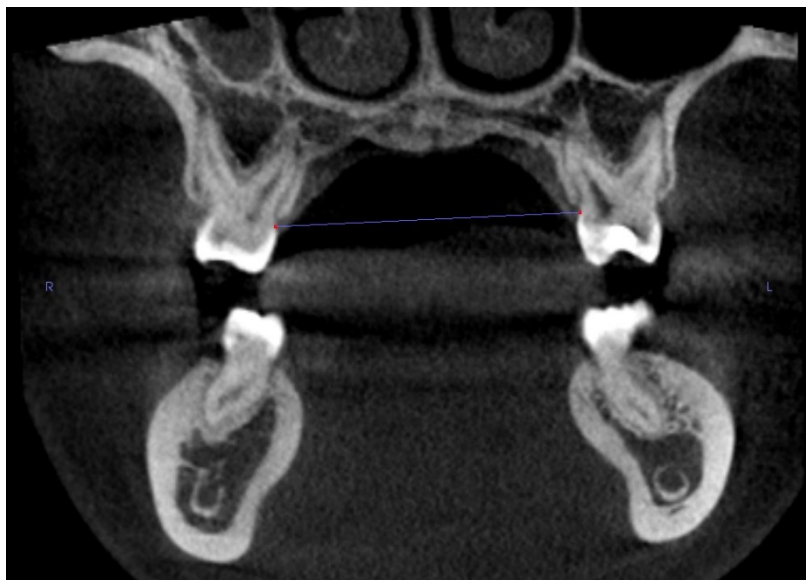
Measurement between central fossae of maxillary first molars on a coronal CBCT image
